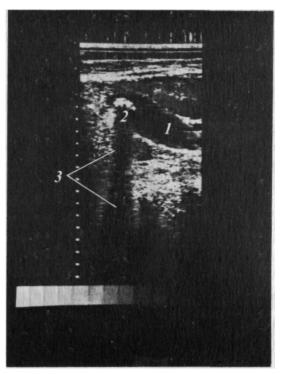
Sonogram of a patient with cholelithiasis. 1—gall bladder cavity; 2—calculus; 3—'acoustic path' (a characteristic sign).
